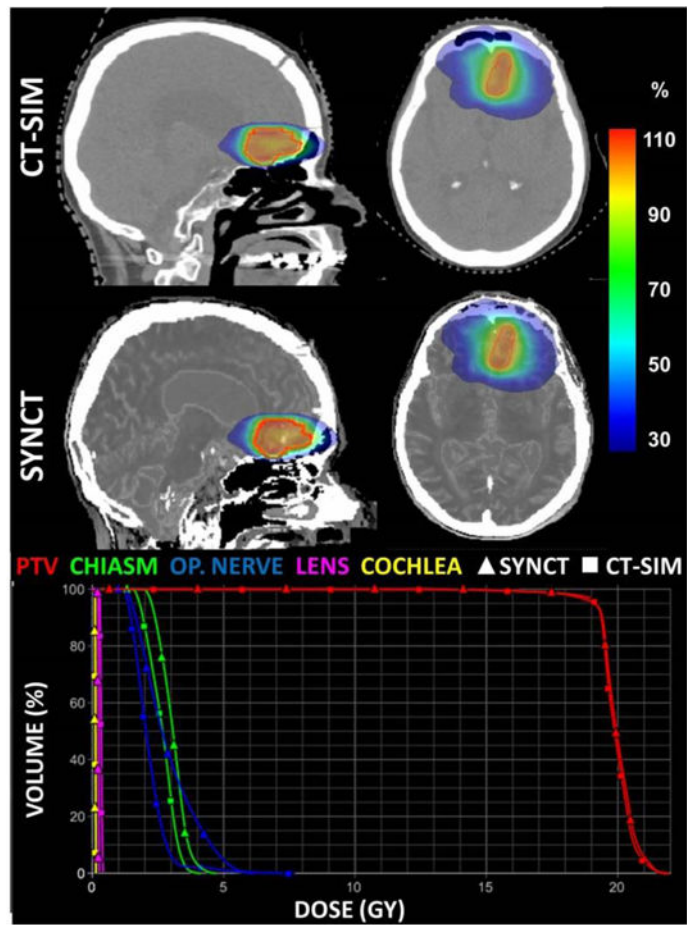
Treatment planning CT and synthetic CT including dosimetric comparison for an average patient brain cancer patient. Dose planes at isocenter (percent dose) for the CT-SIM and synthetic CT. The corresponding dose histogram is also shown highlighting close agreement between dose calculations for a radiosurgery brain case.
